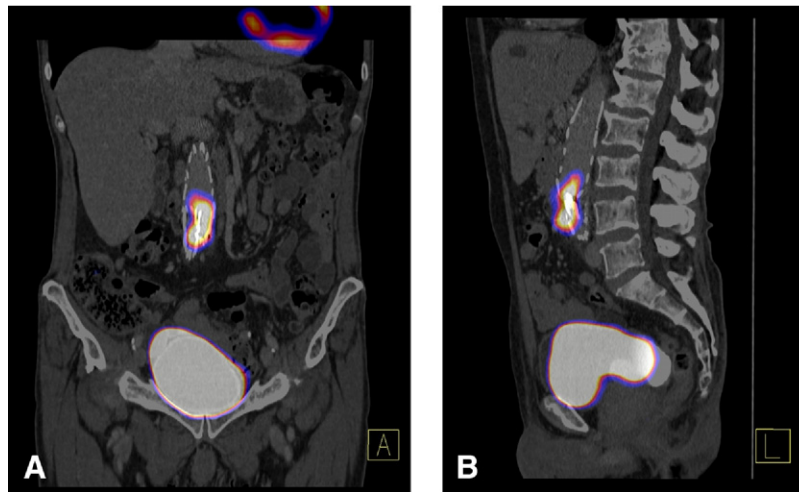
Coronal (A) and sagittal (B) views of fused FDG-PET-CT imaging of an infected aortic endograft. Clearly, a hot spot at the site of the overlap zone between body and endograft limbs is visible.
